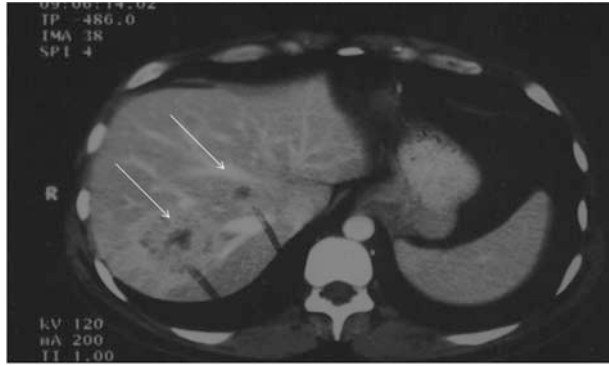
Computed tomography scan from February 24, 2003, shows stable hepatic parenchymal lesions as compared to January 3, 2003 (arrows).
